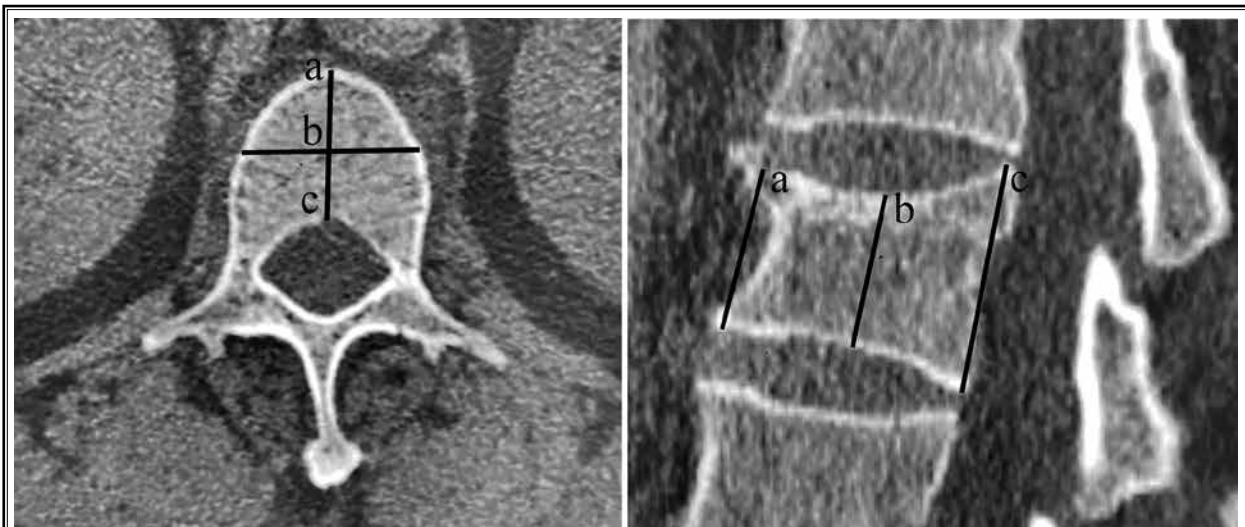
Measurement of VH on 3D CT scans. We drew 2 bisectors on the axial vertebral body view, and the anterior (a), middle (b), and posterior (c) points were constructed. The VH was equal to (a + b + c)/3. VH, vertebral height; 3D, 3-dimensional; CT, computed tomography.
